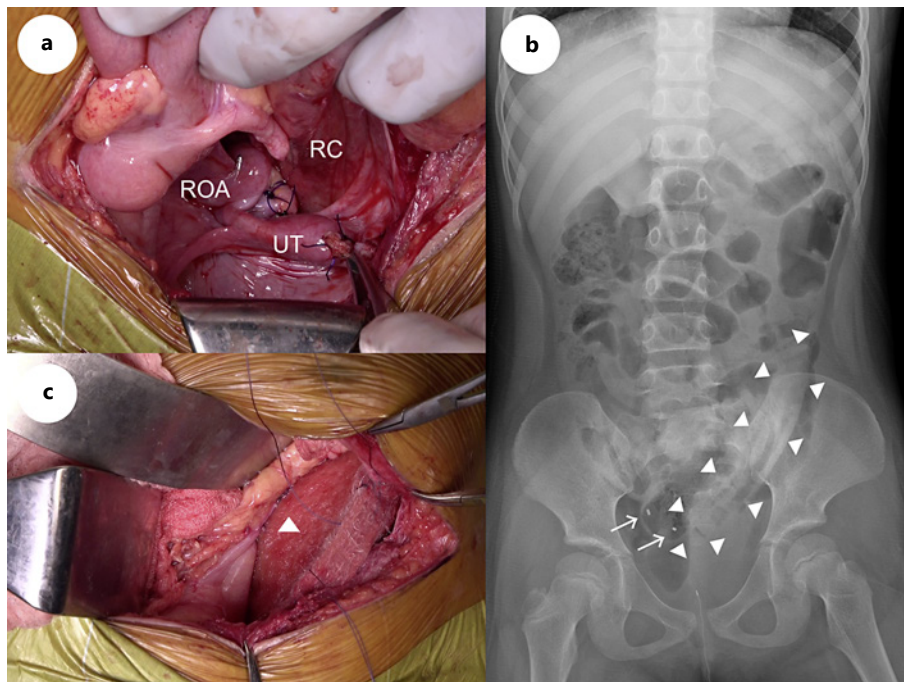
Surgical findings. The patient's colon was mobilized to secure space within the pelvic cavity. a The left OA was sacrificed due to the direct tumor infiltration. The ROA was preserved and fixed to the sacral uterine ligament. b An AS was placed and fixed in the lateral pelvis. c Postoperative abdominal X-ray of the pelvis showing detection of the AS and the ROA (arrows indicating attachment markers). RC, rectum; UT, uterus; ROA, right ovarian appendage; AS, absorbable spacer (NESKEEP) indicated with Δ .
